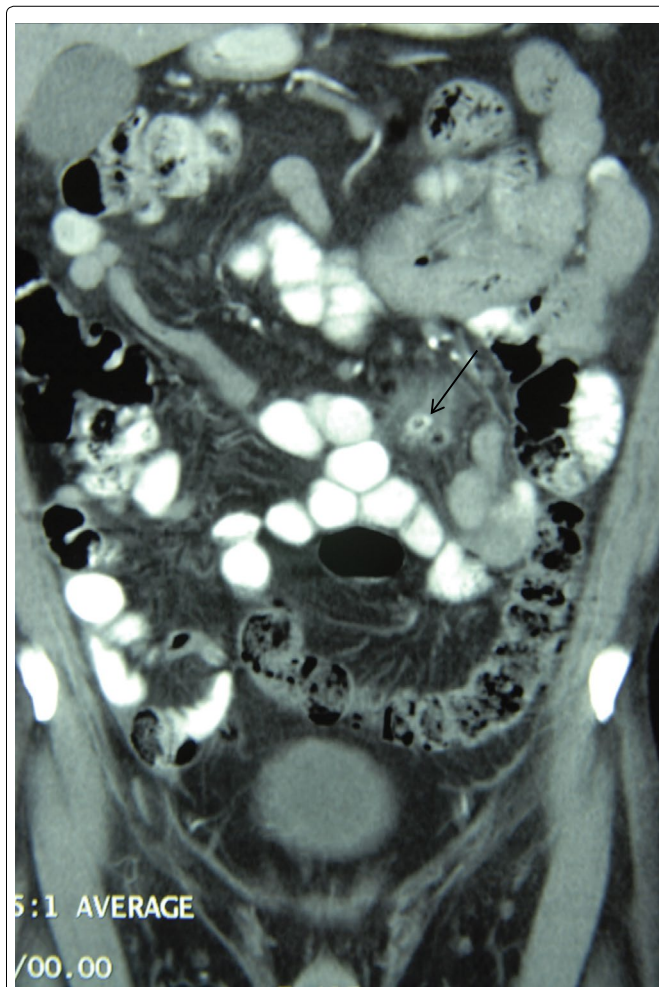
Coronal CT shows multiple small bowel diverticula were identified with surrounding pockets of free air and fluid adjacent to the jejunal diverticula with black arrow.
